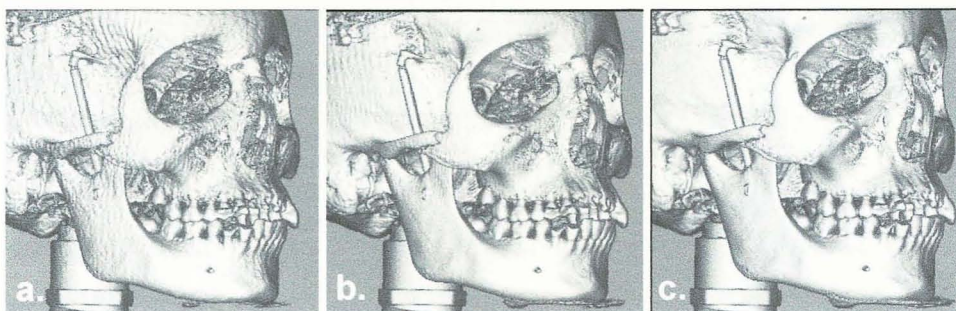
Comparison of 3D shaded surface rendered images from (a.) CBCT 10, (b.) CBCT 20 and, (c.) CBCT 40.
